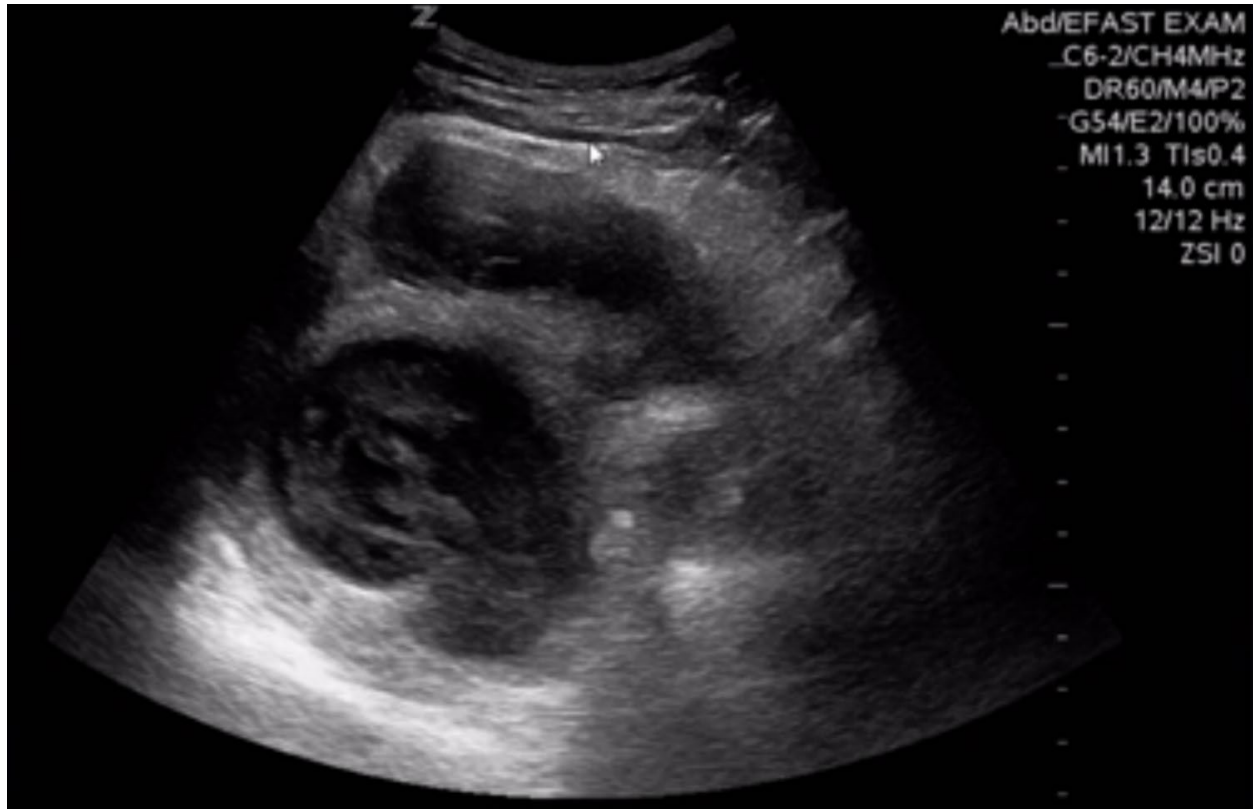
Image courtesy of: Macias M. Ultrasound leadership academy: The basics of pelvic transabdominal ultrasound. In: EM Curious. <http://www.emcurious.com/blog-1/2015/1/8/ultrasound-leadership-academy-the-basics-of-pelvic-transabdominal-ultrasound>. Published January 9, 2015. Accessed August 27, 2018. CC BY 4.0.
